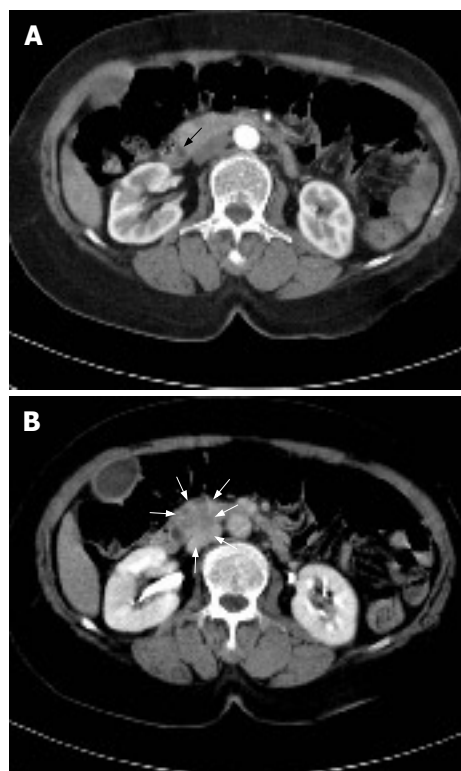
A: Abdominal computed tomography in the arterial phase shows poorly demarcated mass compressing CBD (black arrow); B: In delayed phase, mass (white arrows) at the pancreatic head revealed with relatively well delineated margin.
